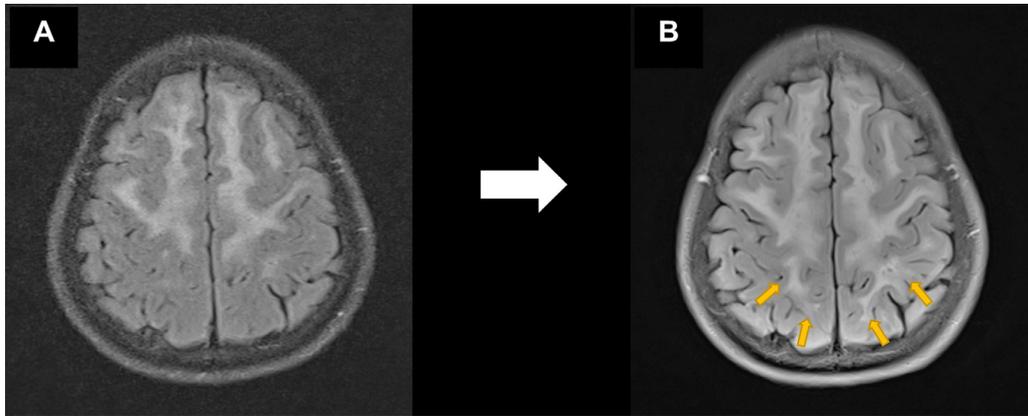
Comparison of the brain MRI obtained between the fifth (A) and sixth attacks (B), with a two-year interval, revealed further progressive T2 white matter hyperintensity behind the central sulcus (arrows).
